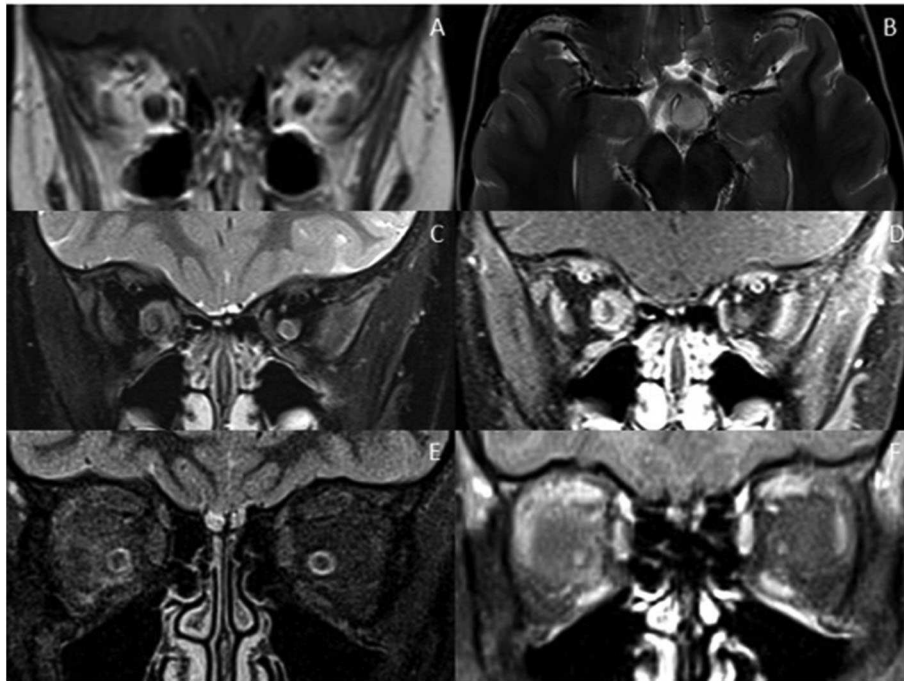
Optic nerve mimics of RDS. (A,B) Optic pathway glioma: The coronal T1-weighted image with contrast shows an expanded intra-orbital right optic nerve. The optic chiasm is expanded on T2-weighted axial imaging (B). (C,D) Optic nerve sheath meningioma: On coronal STIR (C) and coronal T1-weighted image with contrast (D) there is thickening and enhancement of the right optic nerve sheath complex. (E,F) Orbital sarcoidosis: On coronal STIR (E) and coronal T1-weighted image with contrast (F) there is stranding of the intraconal fat, minimal perineural thickening and enhancement.
